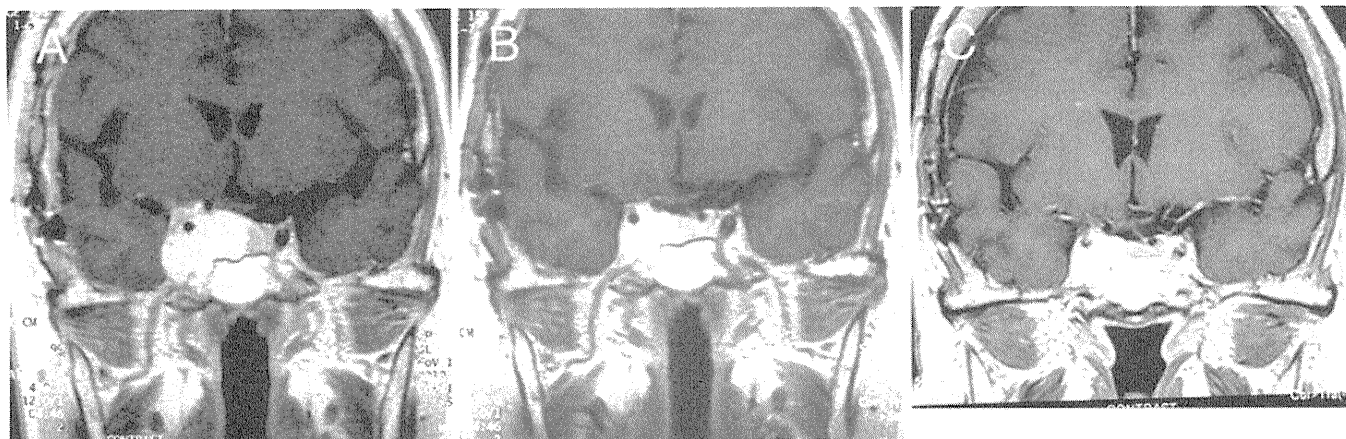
Case 15. Sequential contrast-enhanced T1-weighted coronal MR images obtained before (A), and 12 (B) and 74 months after GKS (C).
